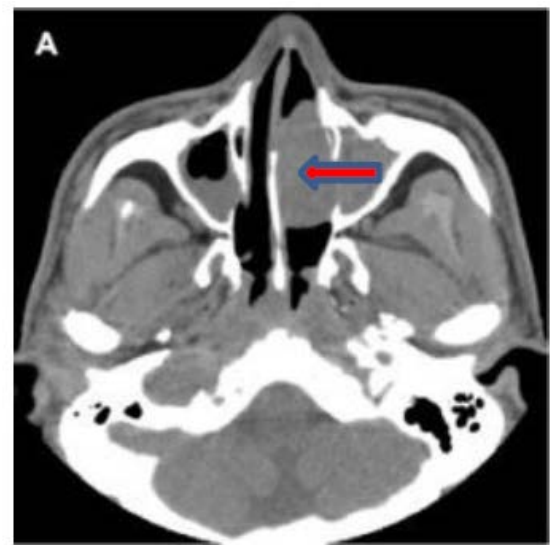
Non-contrast-enhanced PNS CT
